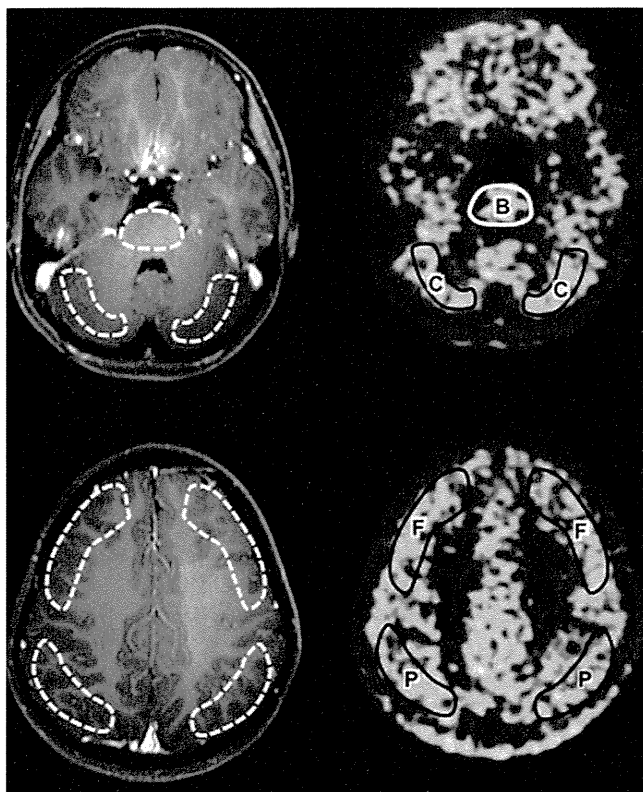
Sample of ^{11}C -MET PET images. ROIs were taken manually in axial plane. Coregistration between MR images and PET scans is adequate. B = brain stem; C = cerebellum; F = frontal cortex; P = parietal cortex.
